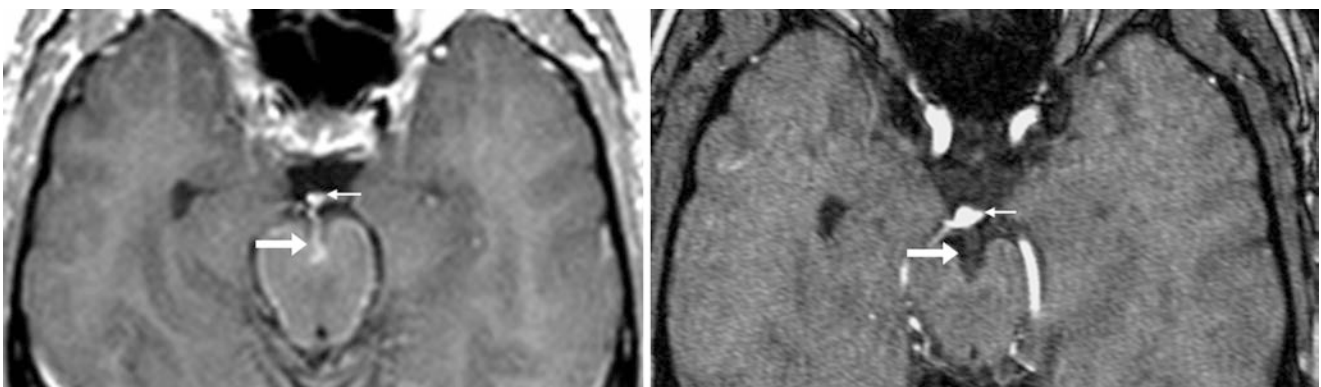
In this 48-year-old, a postcontrast T1WI MRI (*left*) demonstrates the APMV (*large arrows*), situated within the interpeduncular fossa. The APMV appears inseparable from the basilar tip (*thin arrow*).
